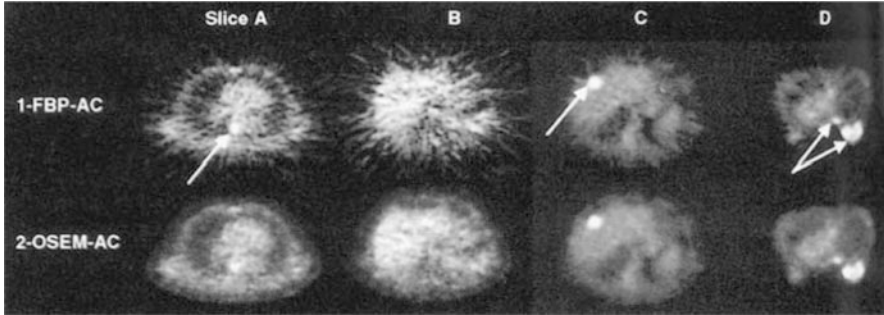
Comparison of filtered backprojection (FBP) and iterative (OSEM) methods with attenuation correction: the (a) lungs, (b) normal liver, (c) liver with tumor, and (d) breast. FBP images with attenuation corrections are noisier than OSEM images with attenuation correction (Reprinted by permission of the Society of Nuclear Medicine from: Riddell C et al (2001) Noise reduction in oncology FDG PET images by iterative reconstructions: a quantitative assessment. *J Nucl Med* 42:1316)
